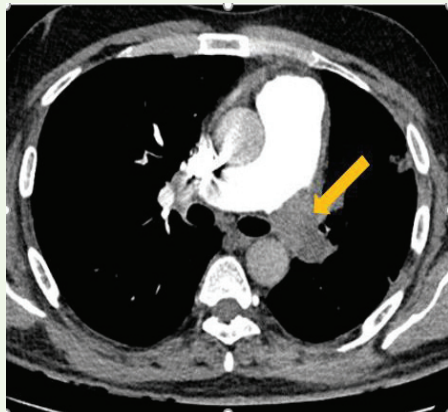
CT pulmonary angiography (CTPA) axial images demonstrate an intraluminal thrombus causing complete luminal occlusion of the left main pulmonary artery, consistent with pulmonary embolism. Despite a total modified Wells score of 1.5 (≤ 4 ; PE unlikely) and a negative age-adjusted D-dimer value of 350, imaging findings confirm pulmonary embolism.
